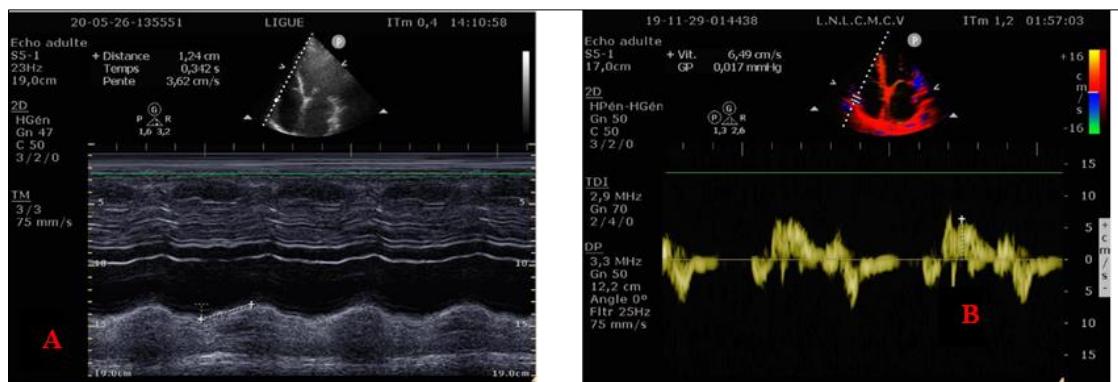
Echocardiographic images demonstrating a reduced TAPSE (Image A) and impaired tricuspid S-wave on tissue Doppler imaging (Image B)
